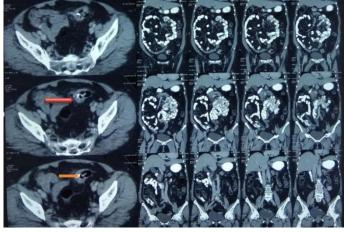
CT abdomen suggestive of bowel edema (Red arrow- bowel edema, Orange edema- foreign body)
